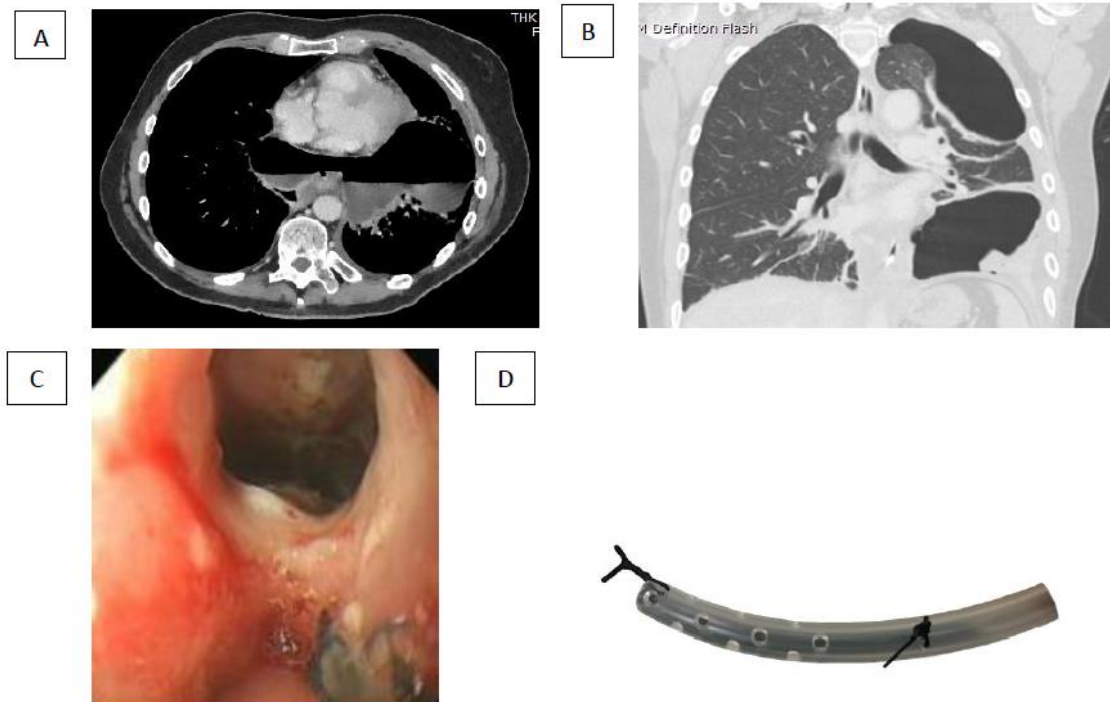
Computed tomographic views of the chest on admission shows an anterior esophageal perforation in combination with bilateral empyema [A] and a left sided pneumothorax [B]. OGD showed an anterior perforation [C] for which a modified EXU drain [Wellspect HealthCare] was positioned in the thoracic cavity through the defect [D].
